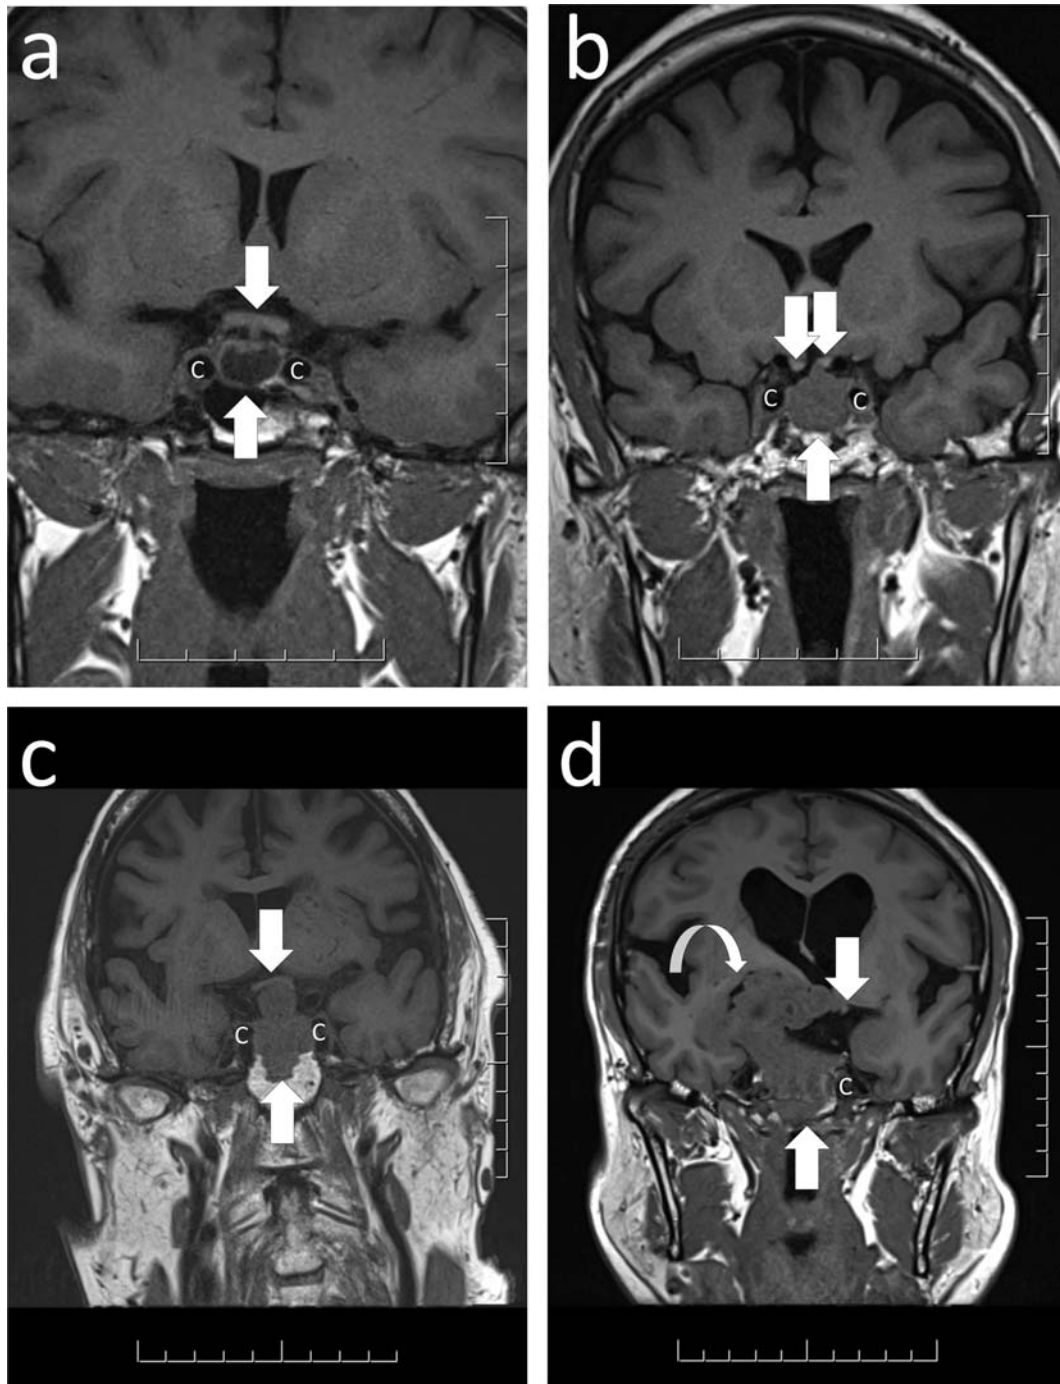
Magnetic resonance imaging of pituitary tumors. The pituitary is located at the base of the brain in the bony structure of the sella turcica (bottom *arrows*) that lies between the cavernous sinuses (C) and below the optic chiasm (top *arrows*). Pituitary tumors can be (A) small, within the pituitary and cystic, (B) slightly invasive into the cavernous sinuses, (C) large and soft, ballooning upwards with a “snowman” shape due to compression by the diaphragm sellae, or (D) giant and aggressively invasive of the brain (curved *arrow*), obstructing cerebrospinal fluid flow and causing hydrocephalus, obliterating the lateral cavernous sinus, and infiltrating inferiorly through bone and into the paranasal sinuses.
